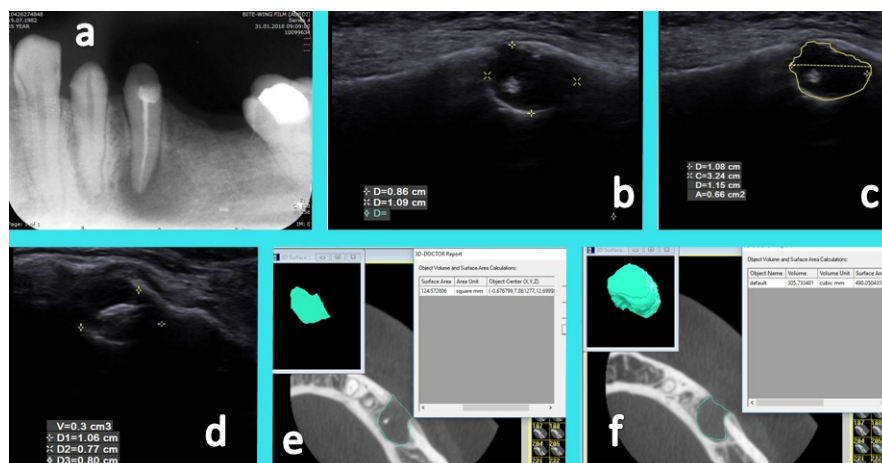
(a) Periapical radiography of a patient with periapical cyst (from Group A) related to left mandibular second premolar tooth. (b) Representative width and depth measurements of the same lesion on ultrasound image. (c) Representative surface area measurement of the same lesion on ultrasound image. (d) Volumetric measurement of the same lesion on ultrasound by using dedicated software. (e) Surface area measurement of the lesion conducted on axial CBCT images by using 3d Doctor software. (f) Volumetric measurement of the same lesion conducted on axial CBCT images by using 3d Doctor software.
